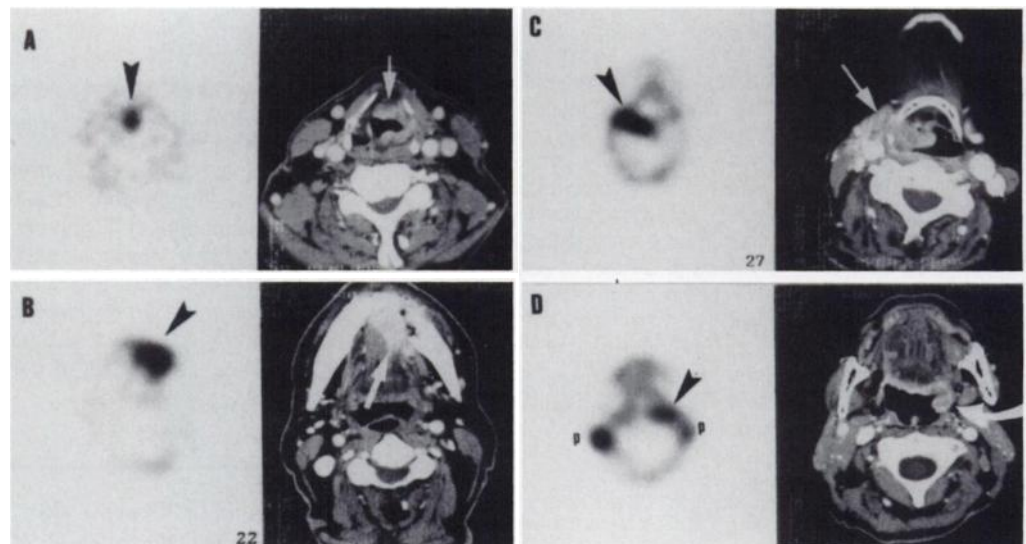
(A) Transaxial ²⁰¹Tl SPECT (left) and CT images after contrast material injection (right) showing (black arrows on SPECT, white arrows on CT) a T2 carcinoma of the larynx, (B) a T3 carcinoma of floor of the mouth, (C) a T3 hypopharyngeal carcinoma and (D) a T2 carcinoma of the oropharynx. In the latter SPECT image, uptake in parotid glands (P) is also observed.
